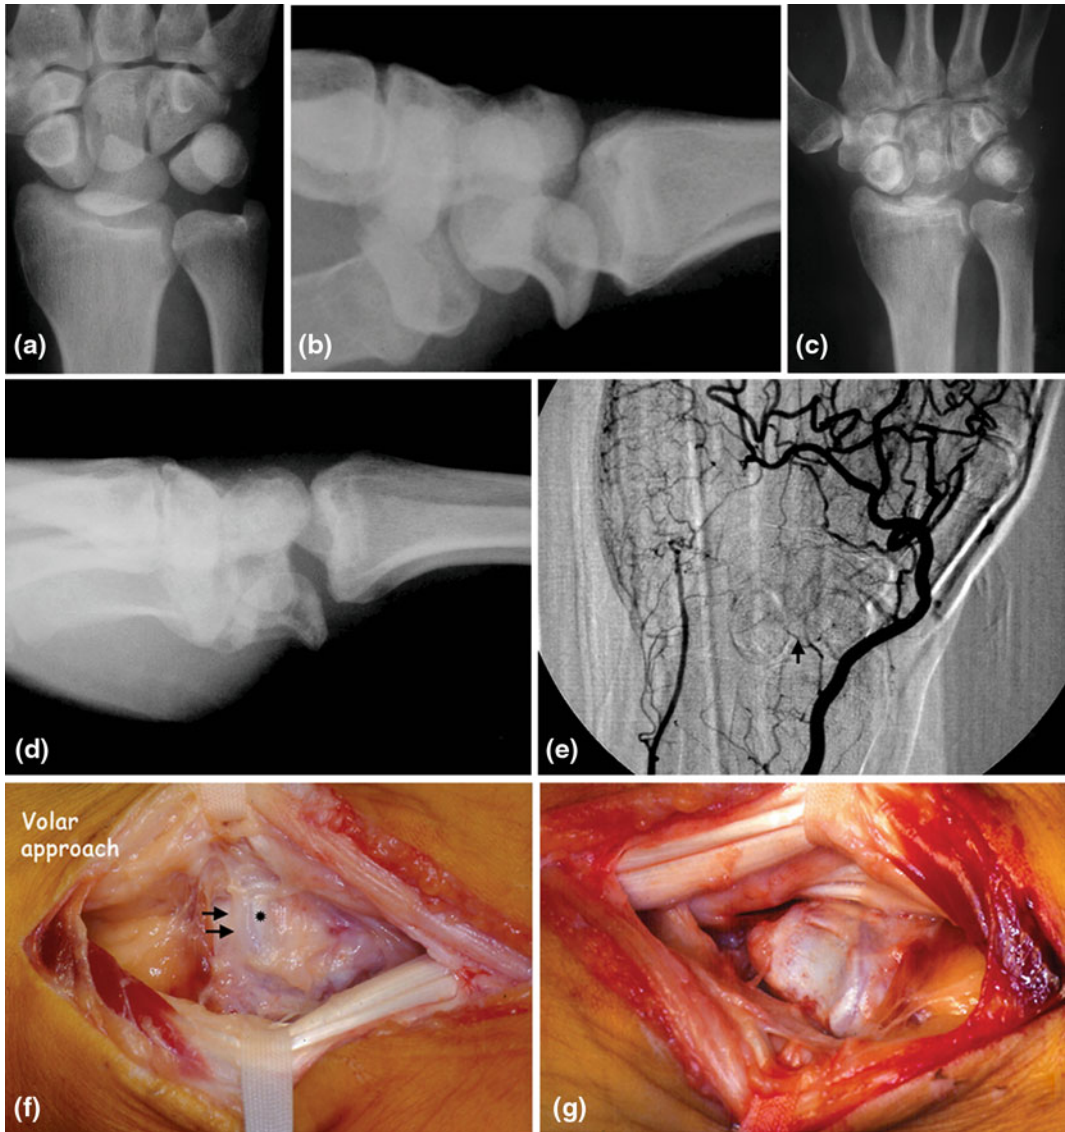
Male, 52-years old, right-handed, with a 4-month old reported injury. It was initially considered a simple injury and a cast was applied. Fifteen days later he was subjected to carpal tunnel release due to numbness of the index and middle fingers. Three months later, pain and numbness continued, he therefore requested medical assistance and a palmar dislocation of the lunate was diagnosed. Initial X-rays (a, b); X-rays after 4 months indicated substantial osteopenia and the displacement of the lunate was upgraded from stage II to stage III (c, d); based on the arteriogram, vascularization of the lunate by a radial artery branch was presumed (e); palmar access exposed the palmar pole of the lunate (*asterisk*), while the distal articular surface was occupied by fibrous tissue
